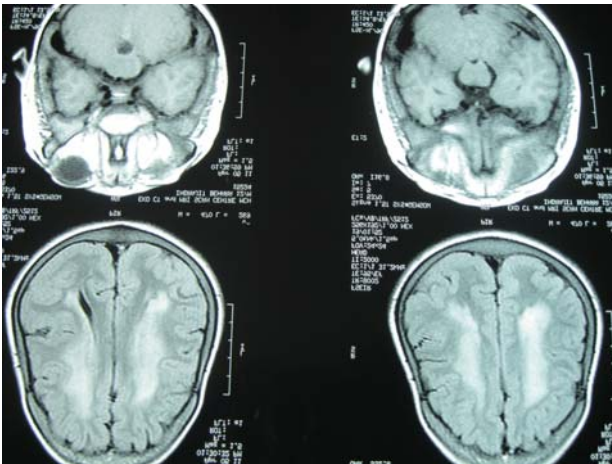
MRI Brain of the older brother
